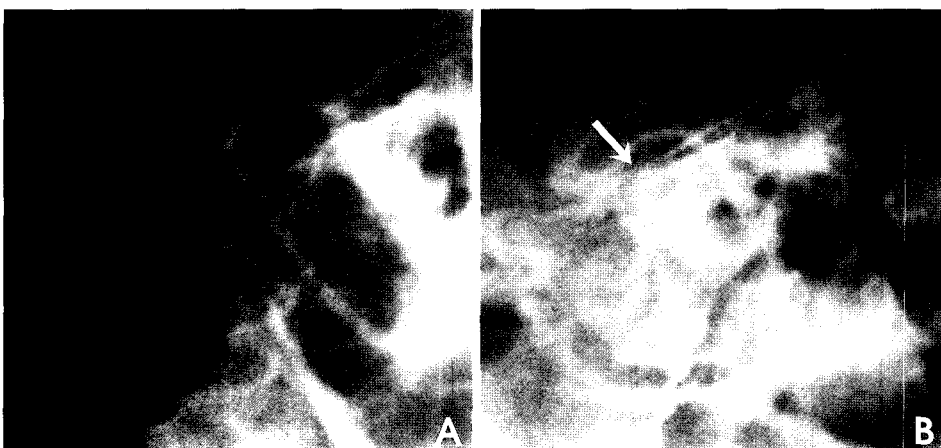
Transcranial radiographs show sclerosis and irregular osseous change on the condylar head at affected side in the operative treatment patient. A, immediately after operation B, 9 months after operation
